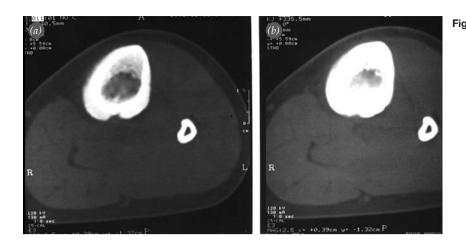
Axial CT images of the proximal part of the tibia show periosteal and endosteal new bone formation.
